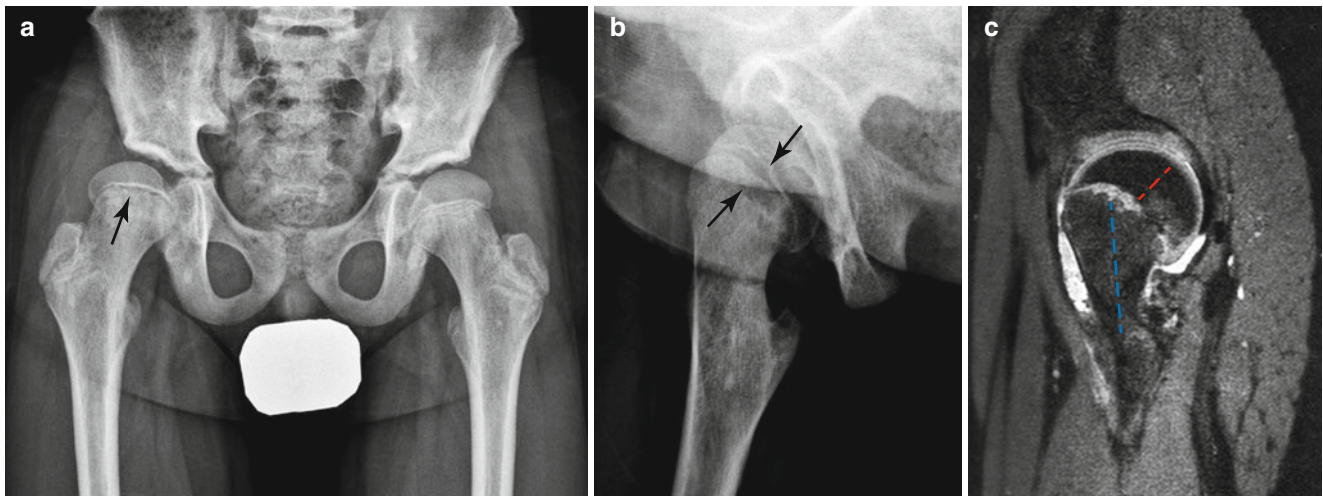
Slipped capital femoral epiphysis, which is an example of Salter-Harris type 1 fracture, in a 12-year-old boy with hip pain. (a, b) Anteroposterior with neutral position and oblique radiographs show asymmetric widening of the physis of the right proximal femur (arrows). (c) 3D VISTA sagittal MR image depicts posterior rotation of the femoral epiphysis (red dotted line) relative to the metaphysis (blue dotted line), indicating retroversion at the epiphyseal-metaphyseal junction
